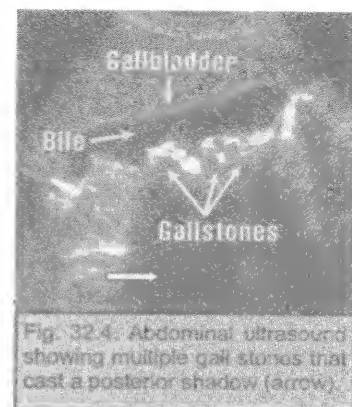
Abdominal ultrasound showing multiple gall stones that cast a posterior shadow (arrow).
